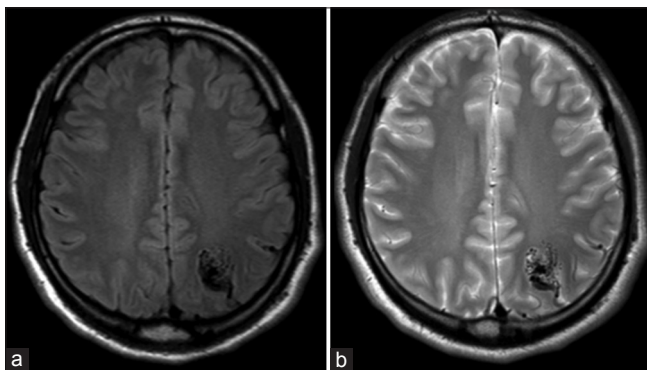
Axial Flair (a) and T2 weighted (b) MRI performed July 21, 2012 demonstrating left parietal AVM
